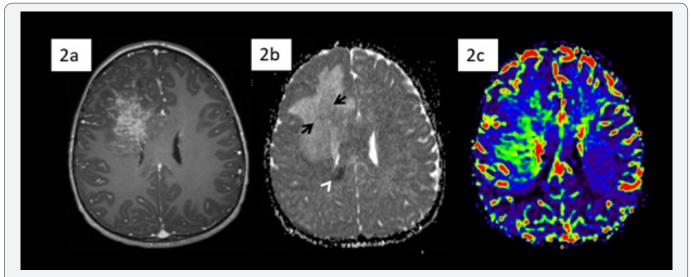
Brain MRI of a 4-year-old male with right frontal lobe mass.
